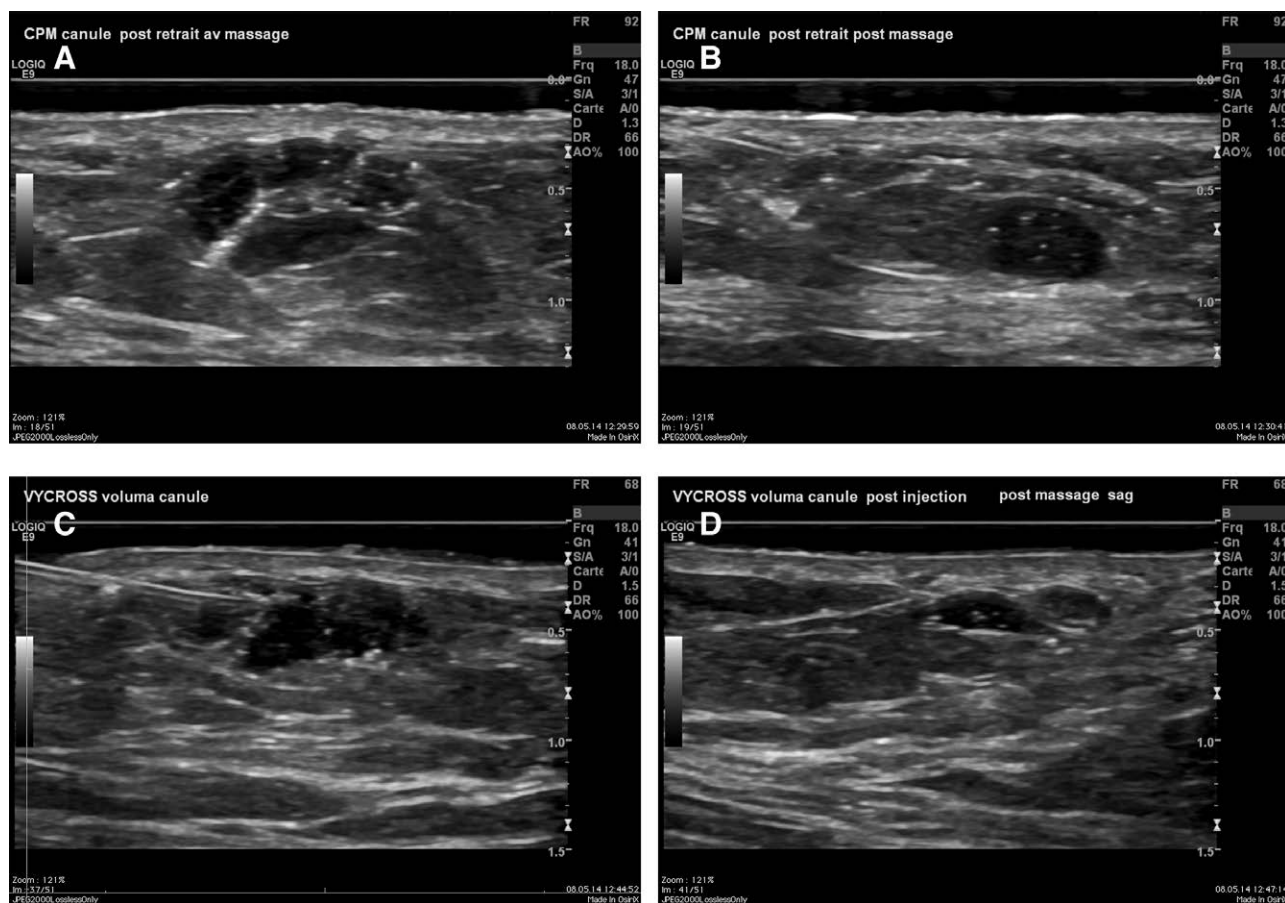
Ultrasound images at day 0 of (A) CPM gel immediately after retrograde fanning cannula injection. B, CPM gel after gentle massage. C, Vycross gel immediately after retrograde fanning cannula injection. D, Vycross gel after gentle massage.
